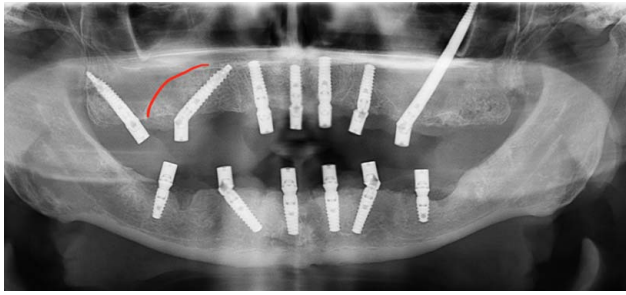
Panoramic radiograph following implant placement with a pterygoid implant in the posterior right, trans-sinus implant in the right quadrant (sinus augmentation outlined in red), anterior implants in the premaxilla and zygomatic implant in the left quadrant.
